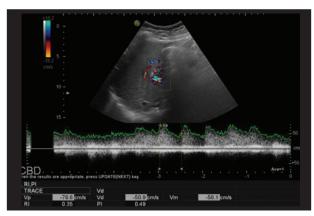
Follow-up ultrasound demonstrating dampened flow within the transplant artery (RI, 0.3–0.35)
